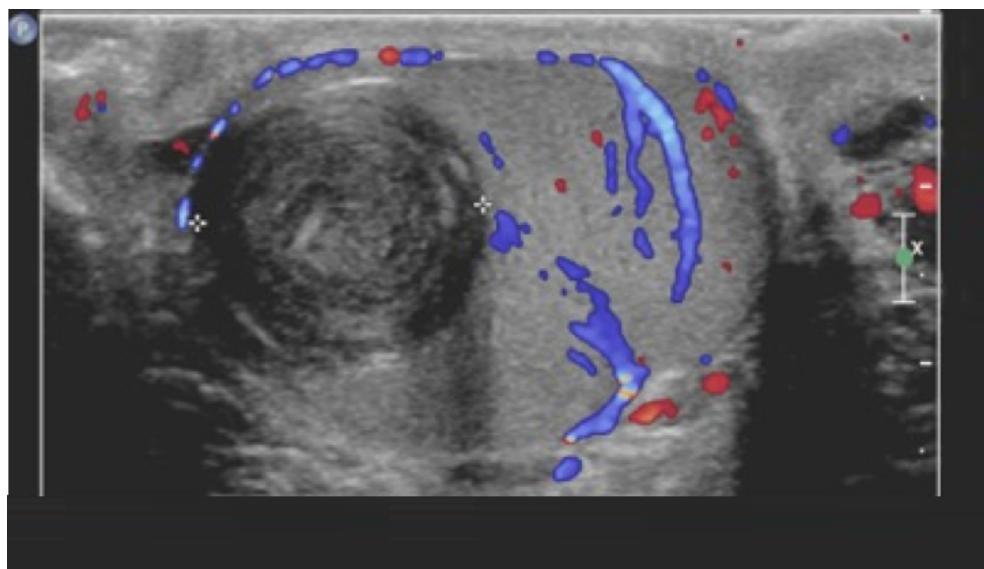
Epidermoid Cyst. An epidermoid cyst, picture here on scrotal ultrasound, appears a well circumscribed, highly echogenic structure with an avascular, laminated interior. Note the lack of blood flow present on the interior of the cyst.
